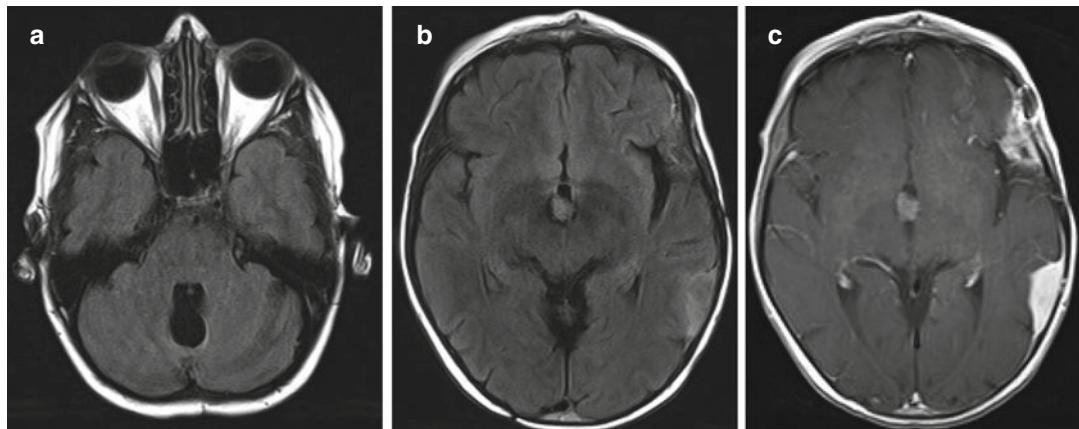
Radiation-induced secondary tumor (meningioma) in a patient treated with surgery and radiation in childhood for medulloblastoma. (a) Initial tumor bed on FLAIR without residual or recurrent tumor. (b) Extra-axial
